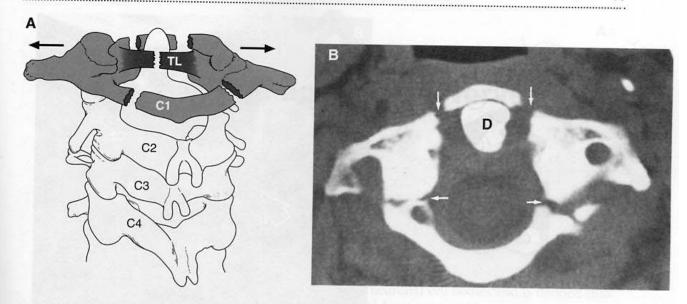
Jefferson fracture. (*A*) The injury has the following classic components: fracture of vertebra C1 at multiple sites, lateral displacement of vertebra C1 beyond the margins of vertebra C2 (arrows), and tear of the transverse ligament (TL). (*B*) CT scan of a Jefferson fracture. Fracture of vertebra C1 at multiple sites (arrows). D = dens. (*B* adapted with permission from Levy RC, Hawkins H, Barsan WG: *Radiology in Emergency Medicine*, St. Louis, CV Mosby, 1986, p 70.)
